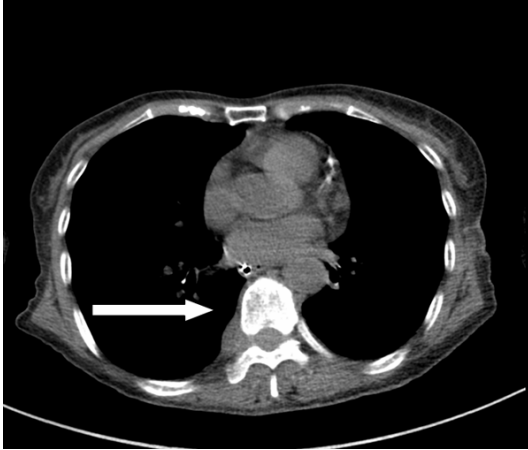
CT image of a mass at T8-10 with ambiguous boundaries.
